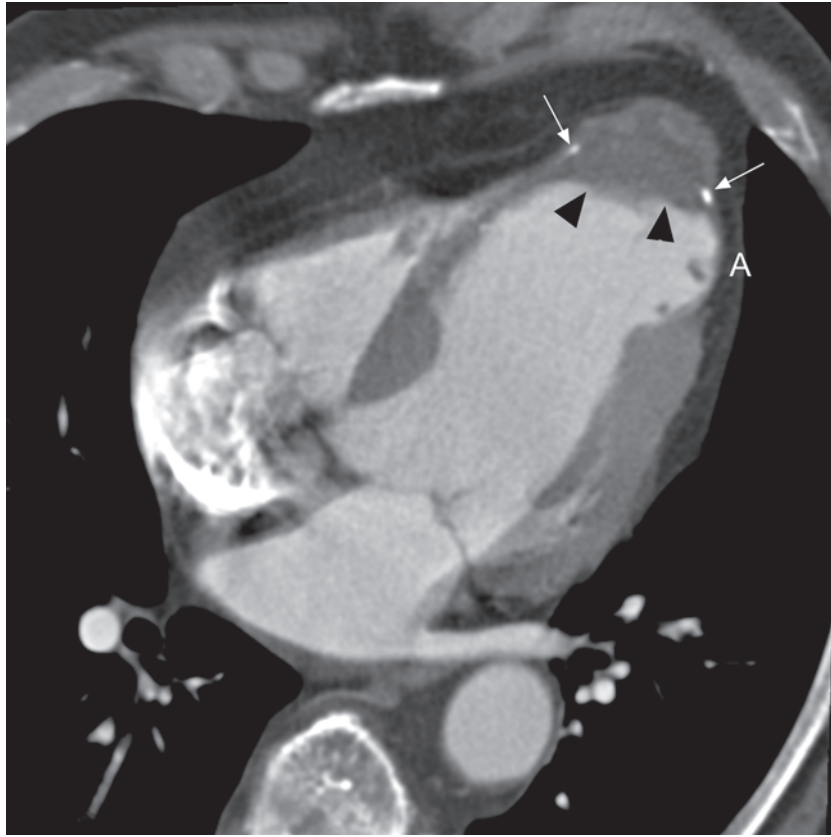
Four-chamber view of a multidetector-row CT data set. Ventricular aneurysm (A) within the apex after myocardial infarction and a thrombus can be delineated (arrow heads). The thrombus show tiny calcifications (arrows).
